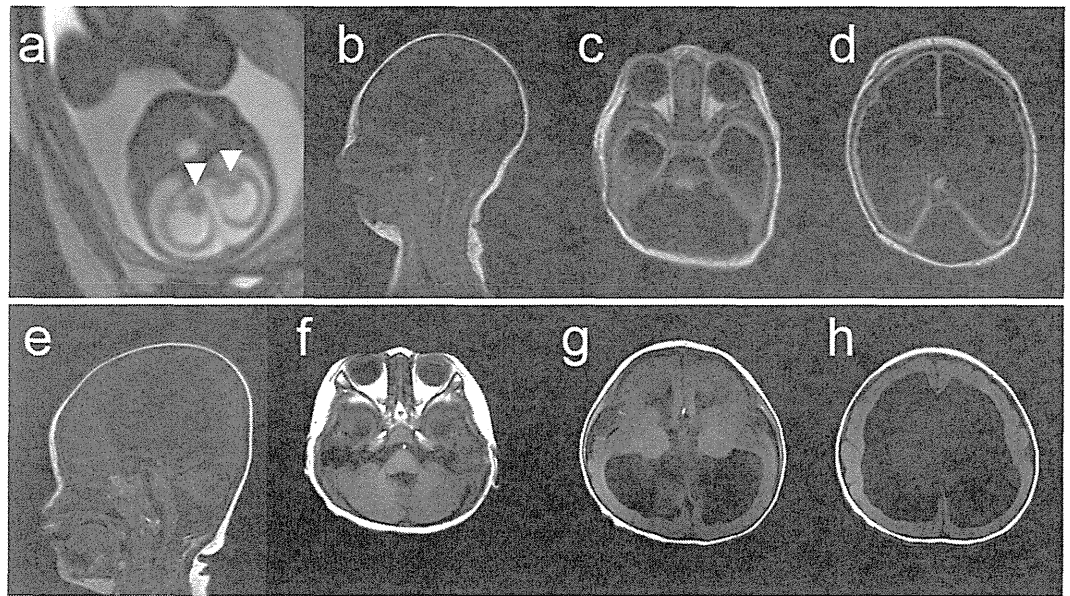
Brain MRI findings of two patients with mutations in *TUBA1A*. (a) Foetal MRI at 28 weeks of gestation of patient 1 (T2-weighted image). White arrowheads indicate the basal ganglia. (b–d) MRI findings at 6 days after the birth of patient 1 (b: T1-weighted image; c,d: Fluid Attenuated Inversion recovery [FLAIR]). The patient showed an extremely thin cerebral parenchyma, hypoplastic brain stem, and agenesis of the cerebellum and corpus callosum. Most of the intracranial space was occupied with cerebrospinal fluid. (e–h) MRI findings at 1 year of age of patient 2 (T1-weighted images). The patient showed marked ventricular dilatation with a thin cortex, agyria, or limited pachygyria, poorly differentiated dysmorphic basal ganglia, agenesis of the corpus callosum, and slightly hypoplastic cerebellar vermis. The brain stem appeared to be normal.
